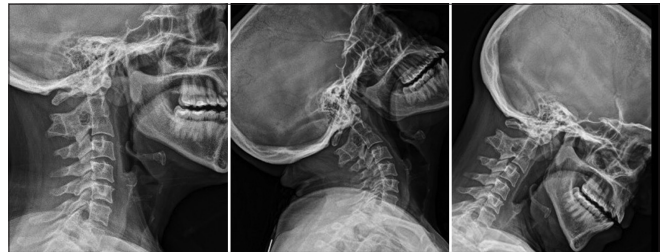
Preoperative lateral cervical spine X-rays in neutral, extension, and flexion.
